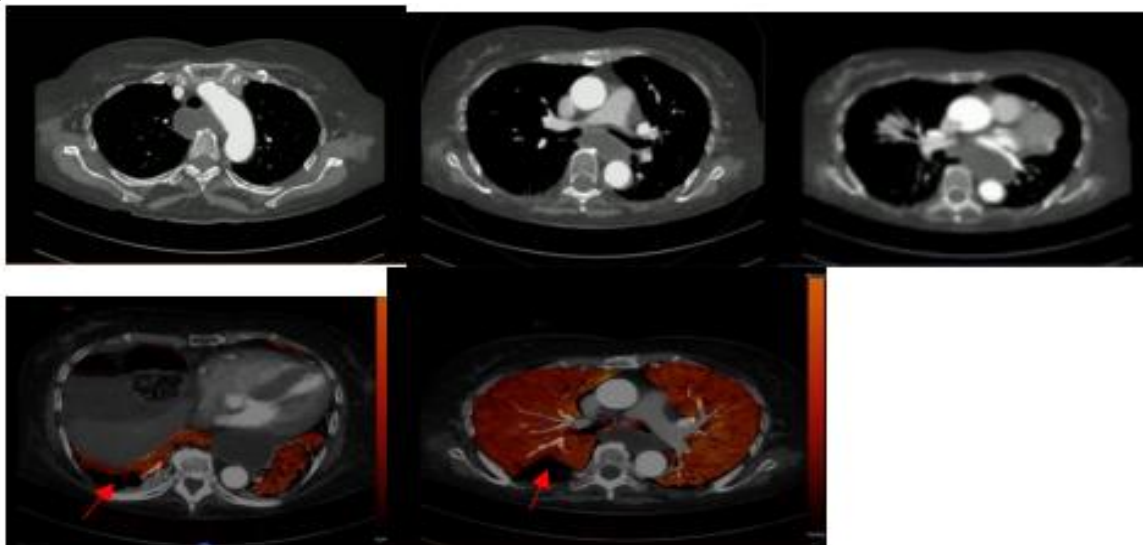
Female patient 50 years old suffering from chest pain normal CT angiography iodine mapping showing wedge shape filling defect at right lower lobe (red arrow).
